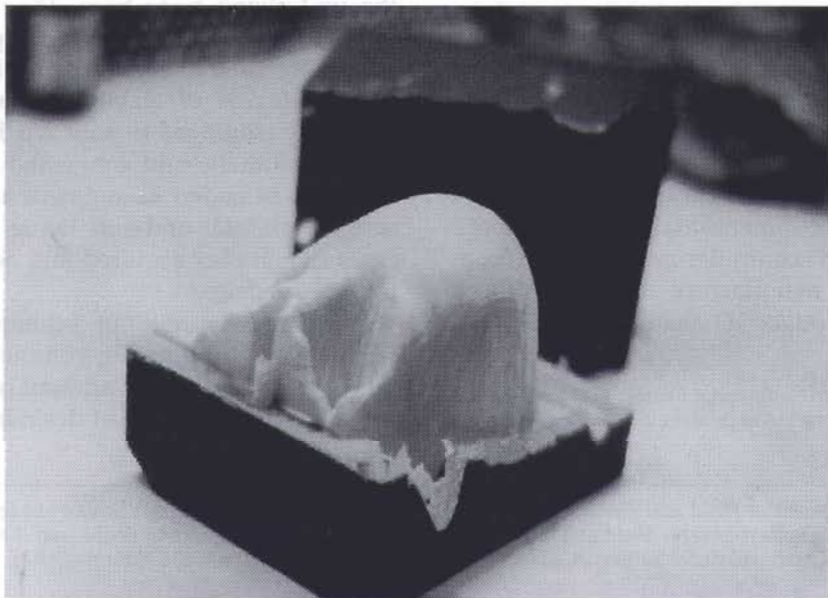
The three-dimensional digital image originating from CT data is transferred via conversion CAD/CAM software to a milling machine to create the mold into which resin is poured, producing the anatomic model.
